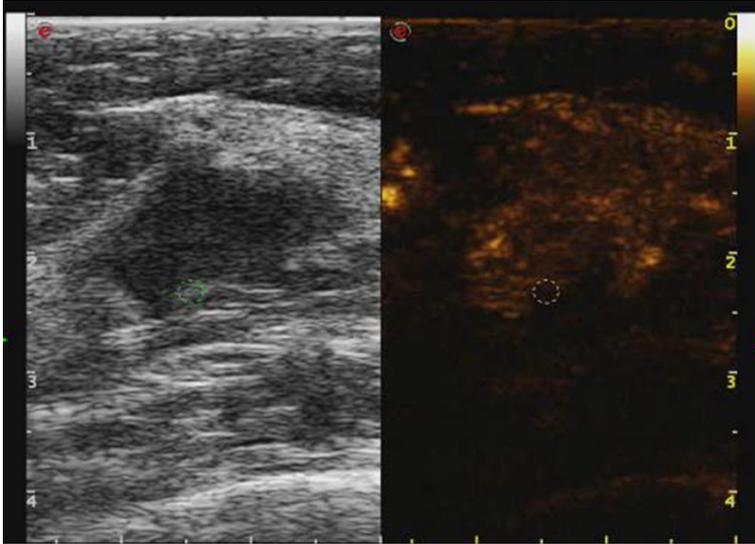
Double-image synchronous display of benign breast lesion by contrast-enhanced ultrasound. The right contrast image showed homogeneous low enhancement and clear margin, with non-enlarged lesion area compared with the left two-dimensional image.
